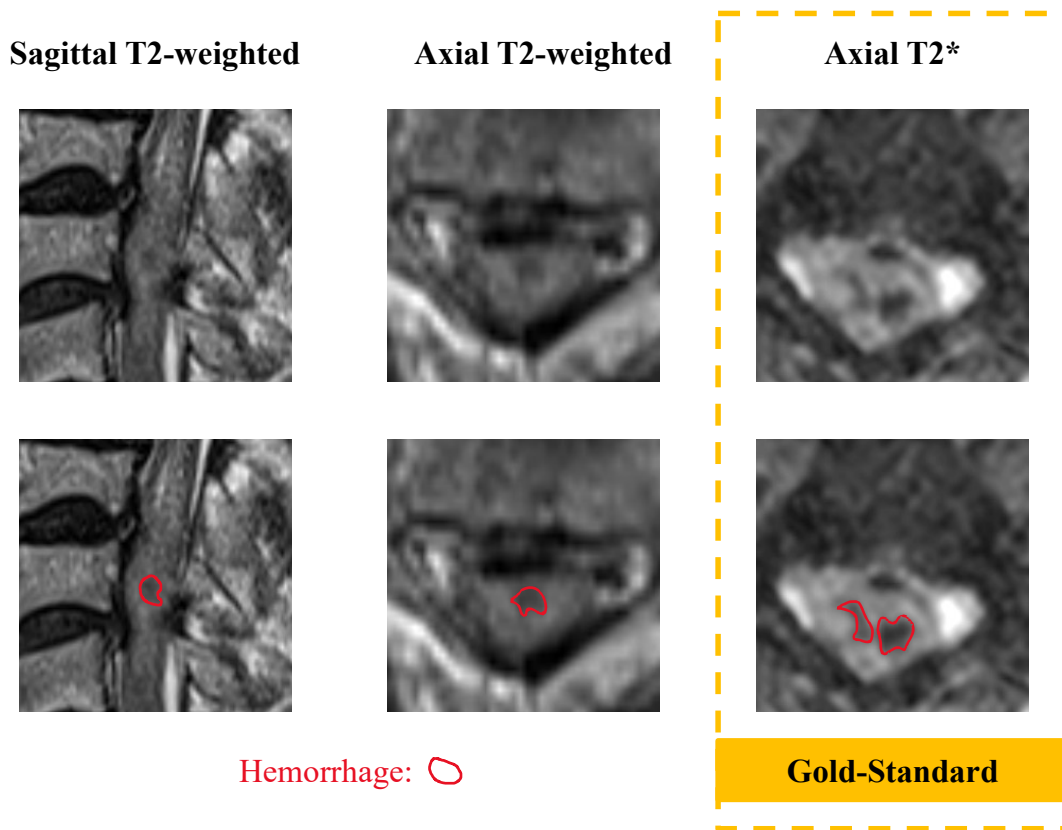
Suspicion and Confirmation of Intramedullary Hemorrhage on MRI
